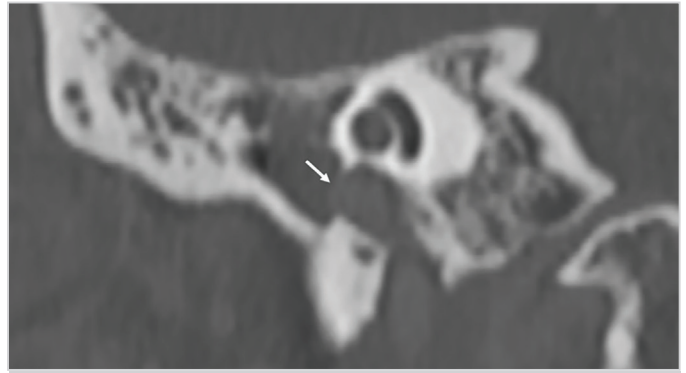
Coronal CT section of the right temporal bone showing dehiscence of the petrous carotid canal (arrow)
